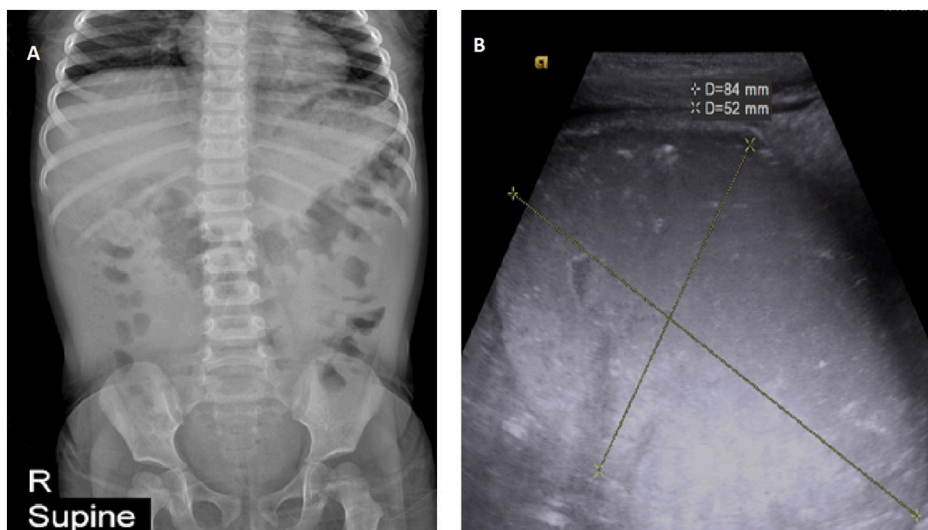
A: Abdominal radiograph shows stomach (arrow) containing food material. No evidence of air-fluid level or intra-peritoneal gas is noted. B: Ultrasound image demonstrates a significantly distended stomach. (Arrow).
